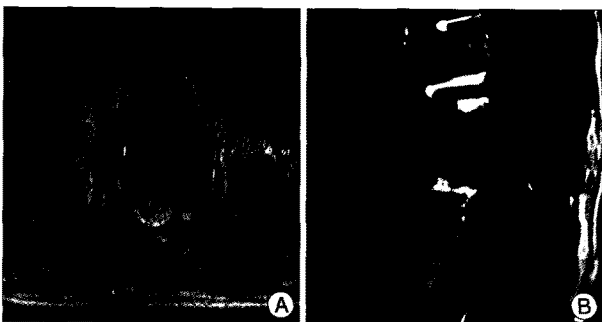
Follow up magnetic resonance (MR) imaging 2 years after surgery. A : The axial T2-weighted and B : sagittal contrast-enhanced T1-weighted MR imaging demonstrates significant diminution of the epidural and vertebral mass.
